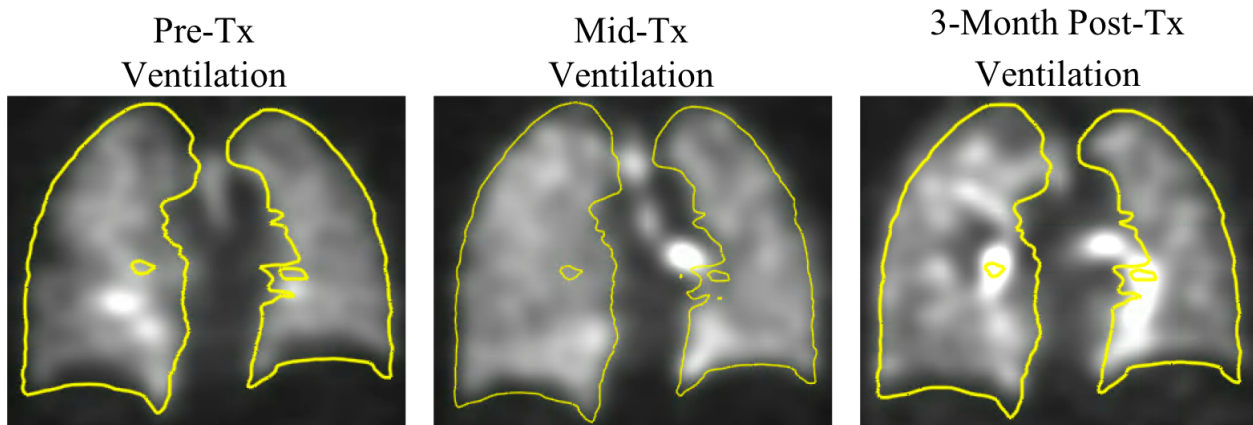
Qualitative example of the ventilation SPECT images for patient UM020 that demonstrates the dose-function response using ventilation intensity during and after radiation treatment.
